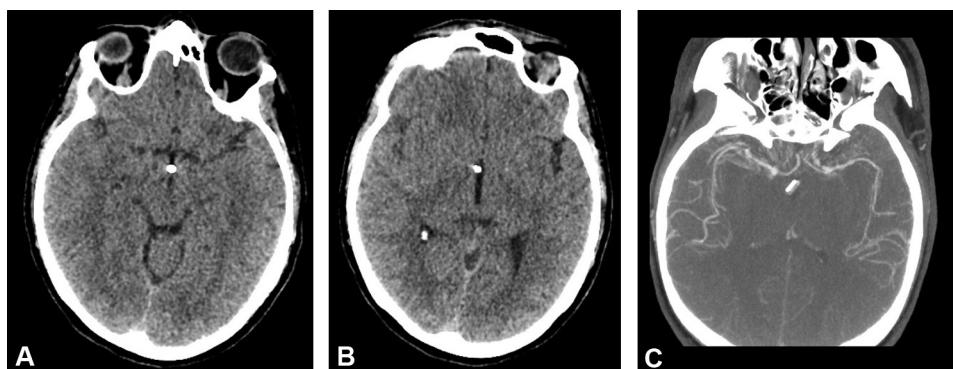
Unenhanced cerebral CT on D12 (A, B). Cerebral CT angiogram of the circle of Willis on axial MIP reconstruction (C).
